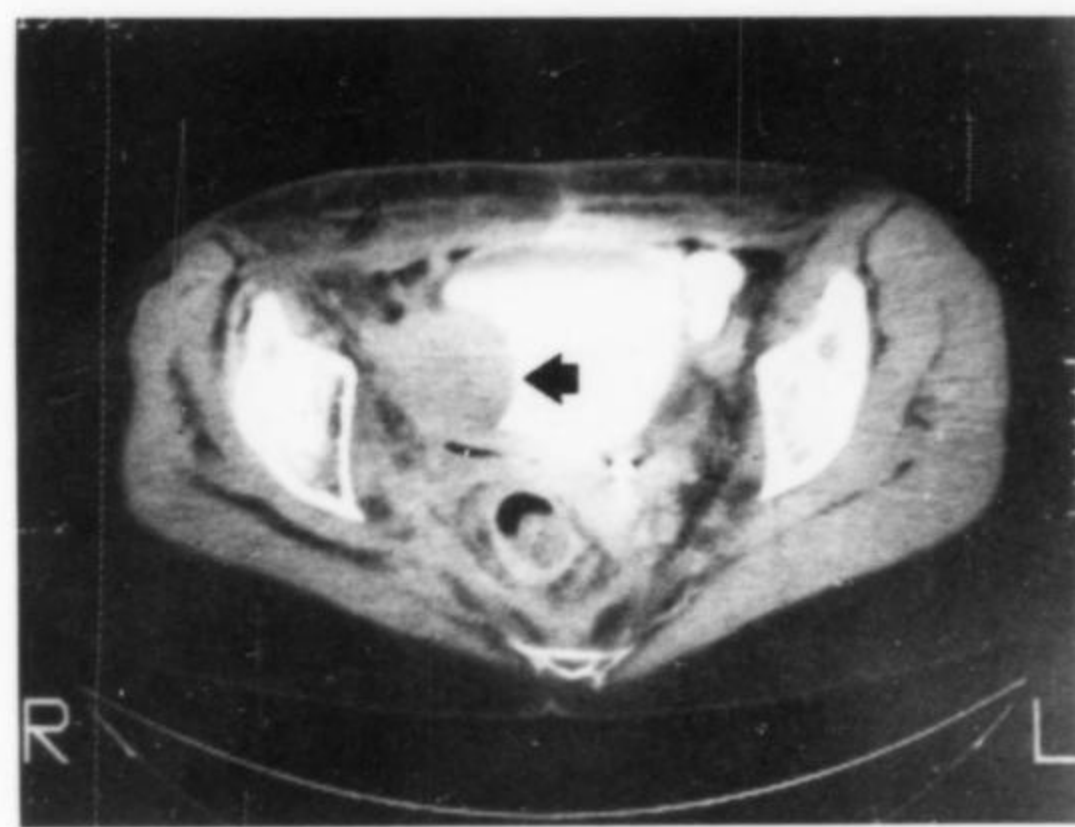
Pelvic CT scan showing recurrent tumor (arrow) after multiple operations and radiation therapy.
